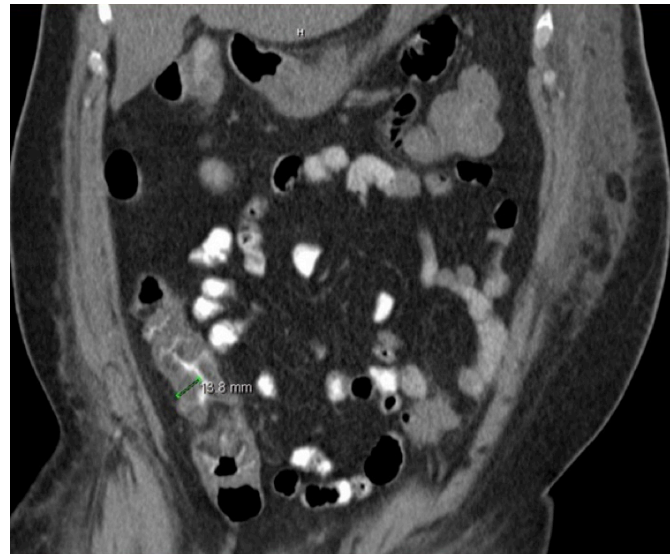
CT scan showing ascending colon wall thickening.
